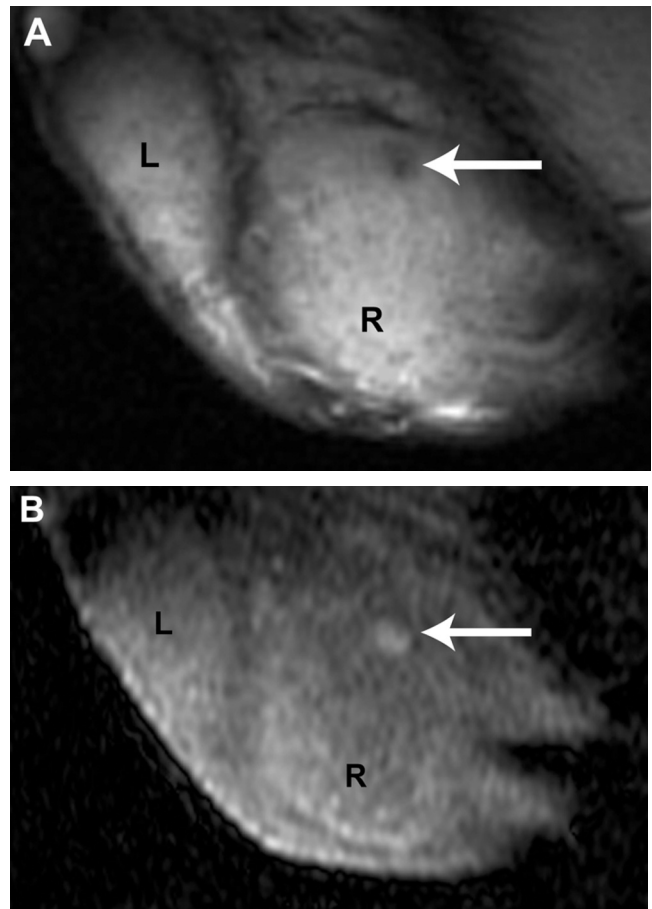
44-year-old male with Leydig-cell tumor. Sagittal T2-weighted MR image of the right testis (R) shows the 3 mm nodule (arrow) with decreased signal intensity compared to the remainder of the testis. An oblique section through the left testis (L) is included in the field of view. B. Sagittal, dynamic, gadolinium-contrast-enhanced MR image performed at 60 seconds following contrast injection shows the nodule to be hyperenhancing compared to the remainder of the right testis (R). The left testis (L) is partly included in the field of view.
